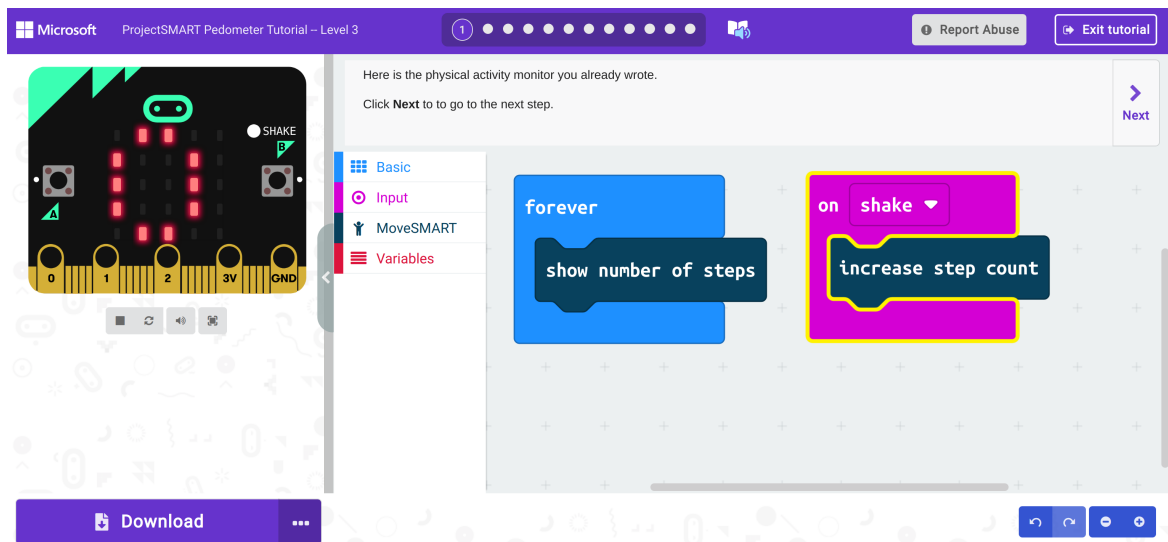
The second CS/CT learning activity in moveSMART, delivered through the MakeCode tutorial platform
